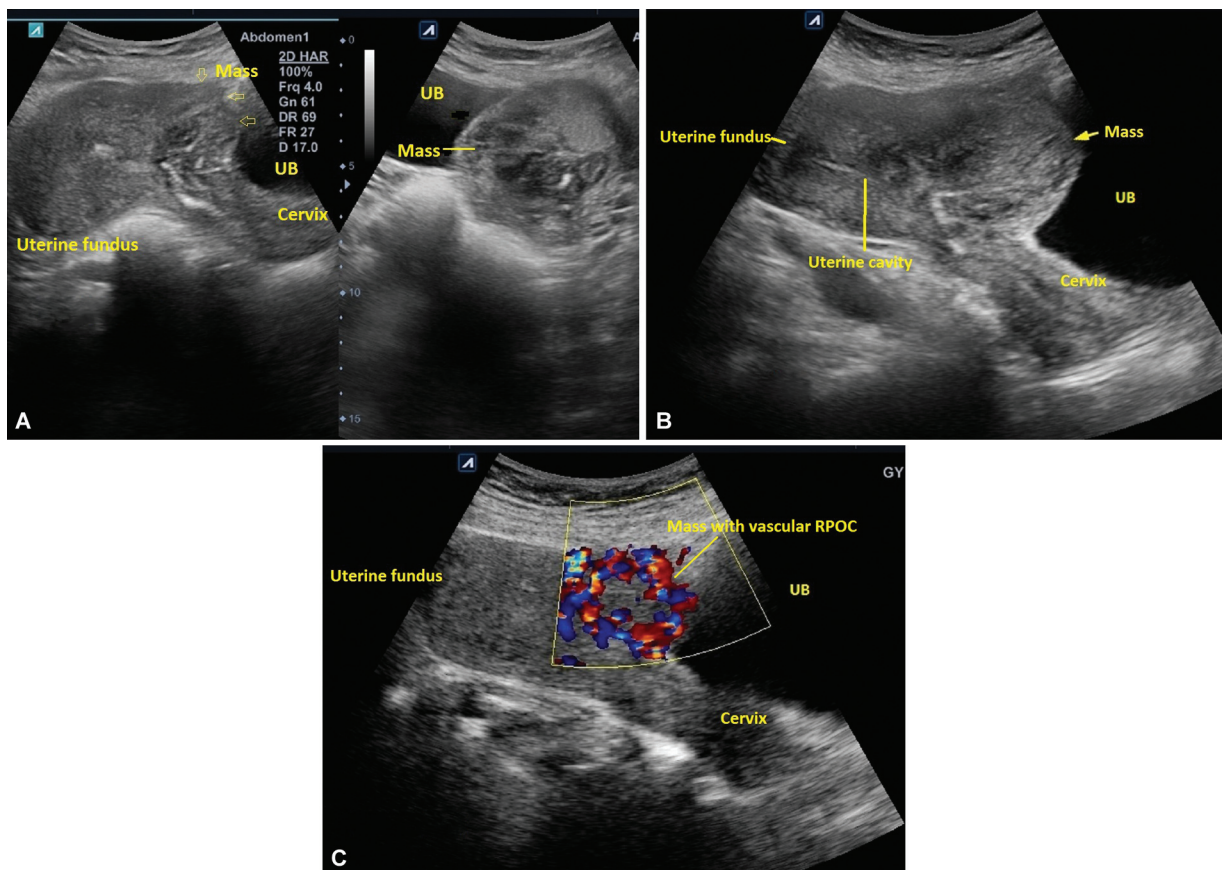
Grayscale and color Doppler images of RPOC at cesarean scar diverticulum. The prior status of CSD was not known. (A–C) A 36-year-old woman, with two previous CS, had heavy vaginal bleeding on the 17th day of taking pills for the termination of a 7-week intrauterine viable pregnancy. (A) Transabdominal mid-sagittal and transverse grayscale ultrasound revealed a heterogeneous mass in the isthmus part of the uterus protruding through the anterior uterine wall (arrows). (B) Grayscale ultrasound performed after 10 days of conservative treatment demonstrated an increase in the size of the mass, resembling a myoma. (c) Doppler imaging indicated vascular RPOC. Surgical intervention following failed conservative treatment confirmed RPOC at CSD upon pathology examination. CS, cesarean section; CSD, cesarean scar defect; RPOC, retained products of conception; UB, urinary bladder.
